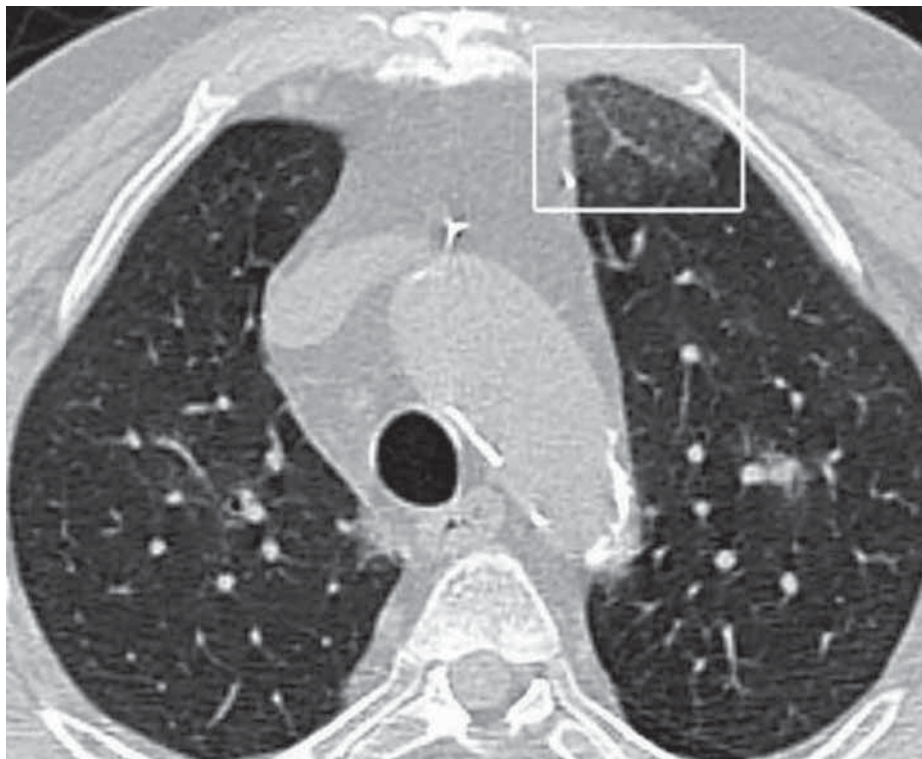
A 67 year-old male patient who had undergone coronary bypass surgery 3 years before presenting with fever and dyspnea. Initial CT showed ground-glass opacity in the left upper lobe anterior segment (square).
